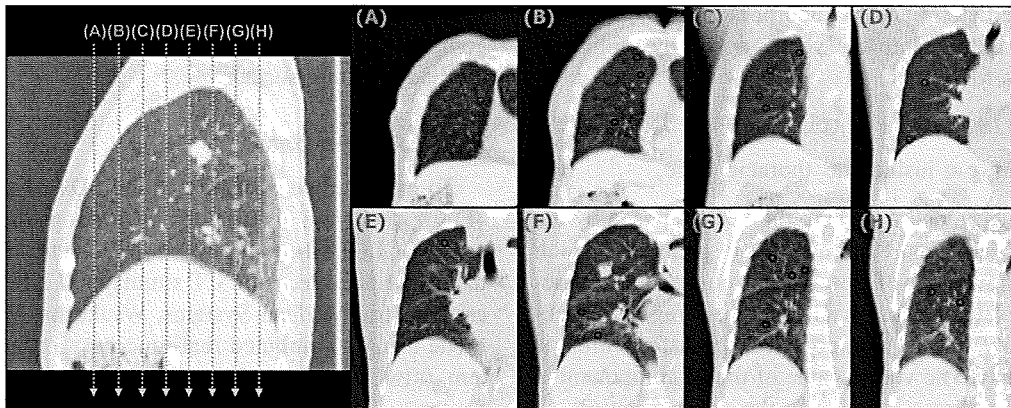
Locations of anatomical landmarks selected for patient 1. Twenty vessel bifurcations were identified within the diseased side of the lung in an end-exhale CT image by an experienced radiation oncologist.
